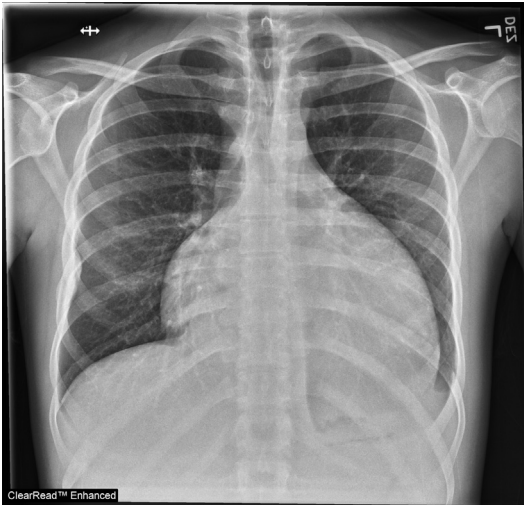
Chest radiograph of a 19-year-old man with Ebstein anomaly demonstrating marked cardiomegaly with clear lung fields and subtle aortic shadow.
